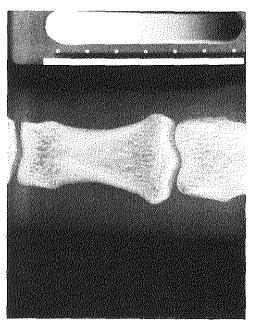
Radiograph of phalanx with a fine bone pattern.
